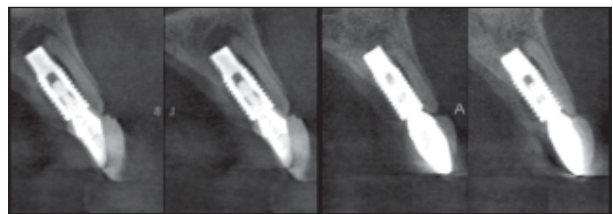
(left) Baseline CBCT cross sections showing the periapical bone defect that was meticulously degranulated prior to implant placement. (right) Cross sections at the 48-month follow-up revealed complete defect fill and approximately 1.5 mm of root resorption. The area of resorption is filled with new tissue with radiographic patterns indicating new bone growth.
